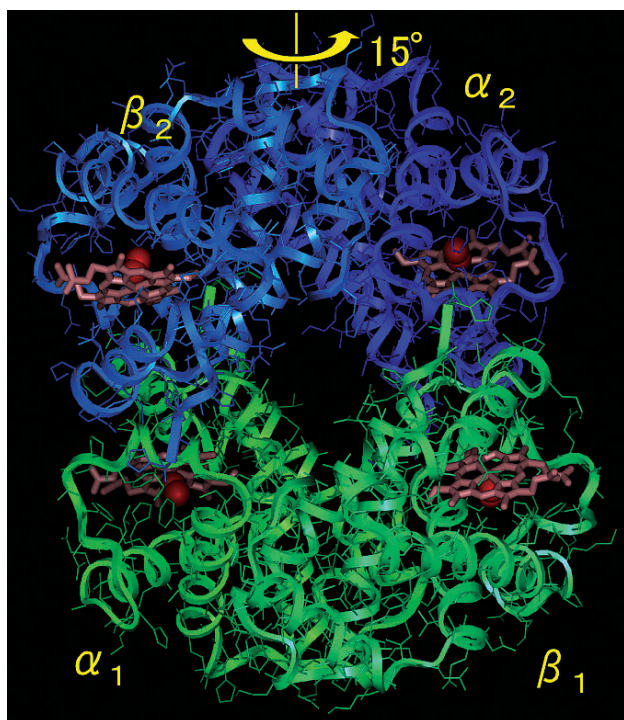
X-ray structure of hemoglobin. Hemoglobin consists of four small proteins (subunits α_1 , α_2 , β_1 , and β_2) which associate with each other and locate at four tops of a tetrahedron. The structural difference between the oxy and deoxy hemoglobin suggests that the $\alpha_1\beta_1$ dimer rotates against to another dimer $\alpha_2\beta_2$ according to the oxygen binding to four hems.
